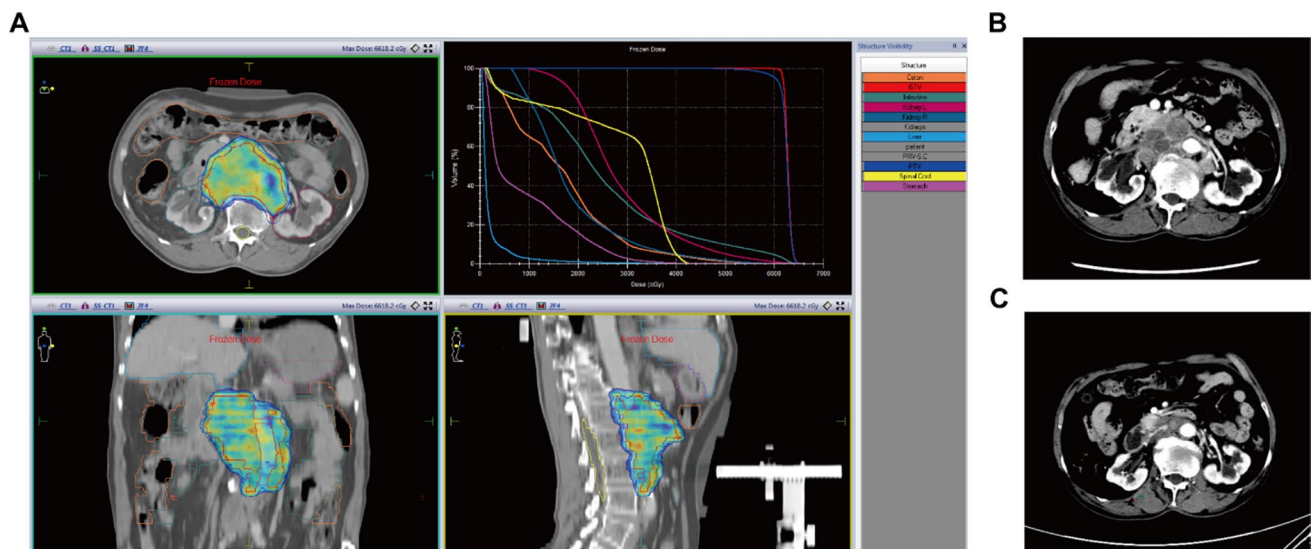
CT scan (arterial phase) for a 53 years old man with right lobe hepatocellular carcinoma and paraaortic lymph node metastasis before and after radiotherapy. A intensity modulated radiotherapy plan and dose-volume histogram, B before radiotherapy, C one month after radiotherapy
